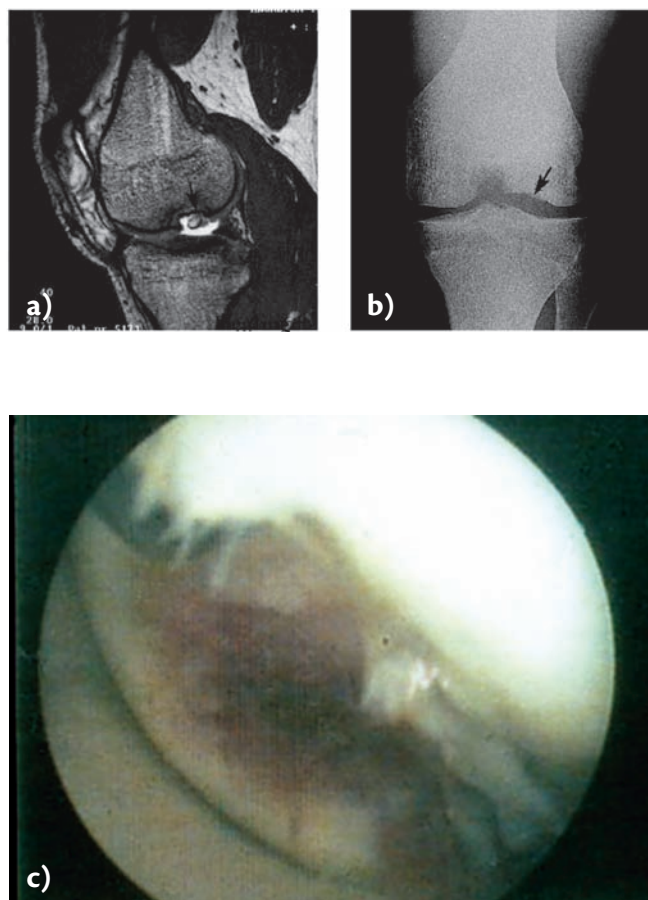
Examination techniques of the knee joint to verify the existence of osteochondritis dissecans (OCD). a) Magnetic resonance imaging of knee; large osteochondritis dissecans of the femur outer joint surface; b) X-ray of femoral condyle with defect after removing osteochondritis dissecans fragments; c) arthroscopy of OCD after the fragment has loosened and has become a free body.
